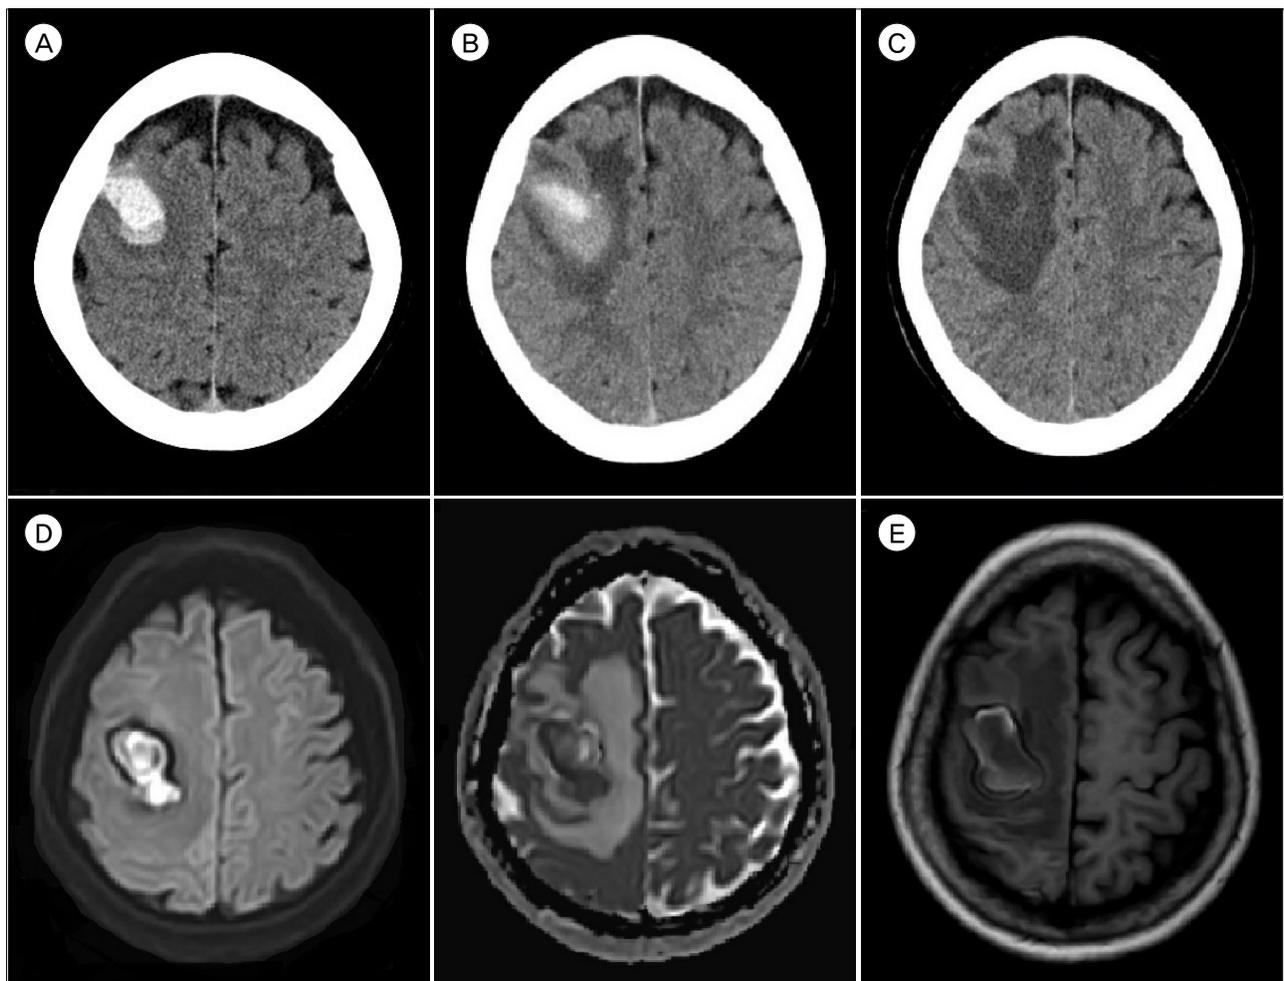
(A) Initial CT images. Pre-contrast CT shows high density ICH on the right frontal lobe. (B) Follow-up CT images at 3 weeks. Pre-contrast CT shows an initial volume reduction of hemorrhage and resolution. (C) Follow-up CT images at 6 weeks. Pre-contrast CT shows a mass-like lesion on the right frontal lobe with severe swelling. (D) Diffusion-weighted MRI. (E) MRI shows a ring-enhanced mass-like lesion. CT = computed tomography; ICH = intracerebral hemorrhage; MRI = magnetic resonance images.
